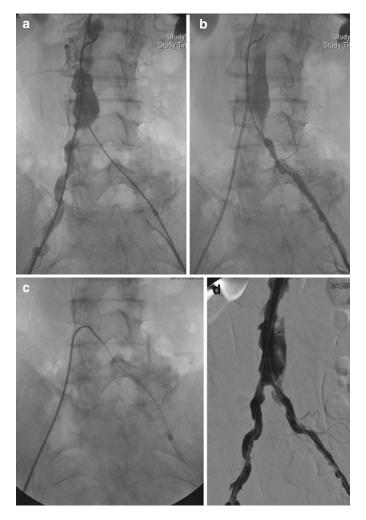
(a) Aortogram showing R CIA stenosis, L CIA occlusive disease. (b) L iliac retrograde sheath angiogram confirming aorto-iliac dissection and no true-lumen re-entry after L retrograde iliac crossing attempt. (c) Switch to antegrade wire passage. (d) Now true-lumen access confirmed for L sided wire (dissection still filling). (e) Kissing bilateral iliac stents placed. (f) Completion angiogram, with no further filling of dissection (contrast visible is retained contrast, CT scan following day confirmed no dissection)
